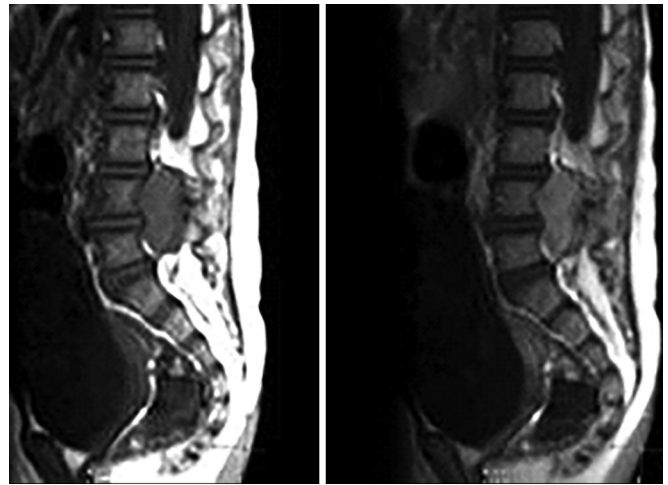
Magnetic resonance imaging (MRI) of dorsolumbar spine showing neuroblastoma with intraspinal extension
